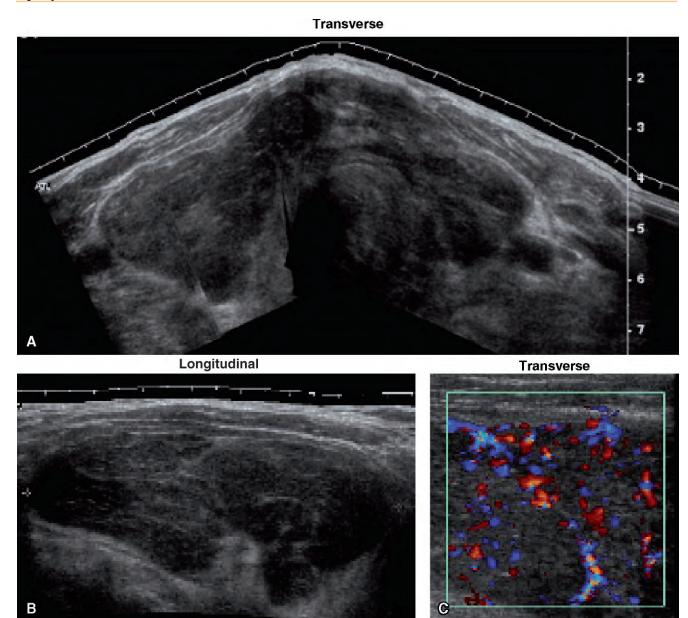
Ultrasound of lymphoma in both lobes. A, Transverse. B, Longitudinal, sagittal diameter: 75 mm. C, Color Doppler, transverse.
